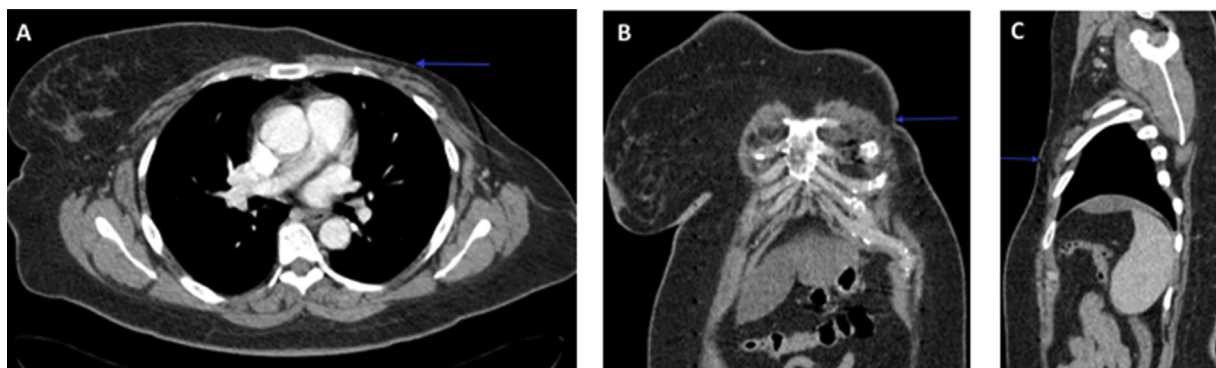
Selected images of a CT chest post IV contrast in the arterial phase and in soft tissue window. A). Axial view B). Coronal view. C). Sagittal view showing post-surgical changes noted (left mastectomy) with no recurrent/residual masses seen (blue arrow).
